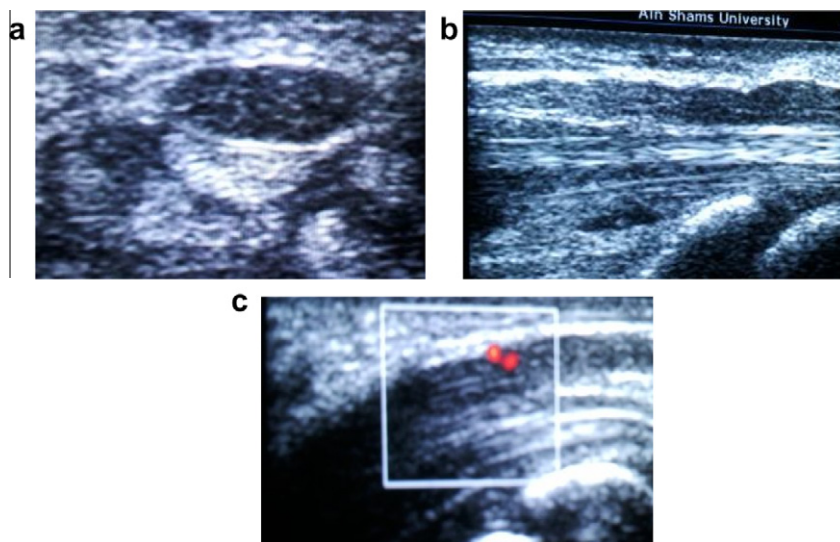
(a & b) Transverse and longitudinal images of the median nerve at carpal tunnel showed nerve edema and significant swelling ($CSA = 28 \text{ mm}^2$), as well as bowing of the flexor retinaculum. (c) Power Doppler showed +ve sign of intraneural hypervascularization.
